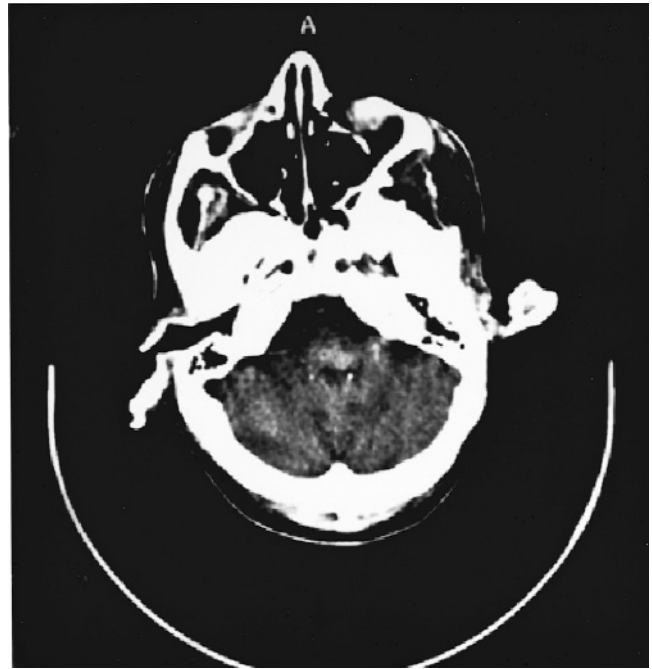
Brainstem tuber with distortion of the floor of the fourth ventricle as seen on an axial noncontrast computed tomographic scan. Two small subependymal nodule calcifications are evident. Reproduced with permission from DiMario FJ.²⁹
